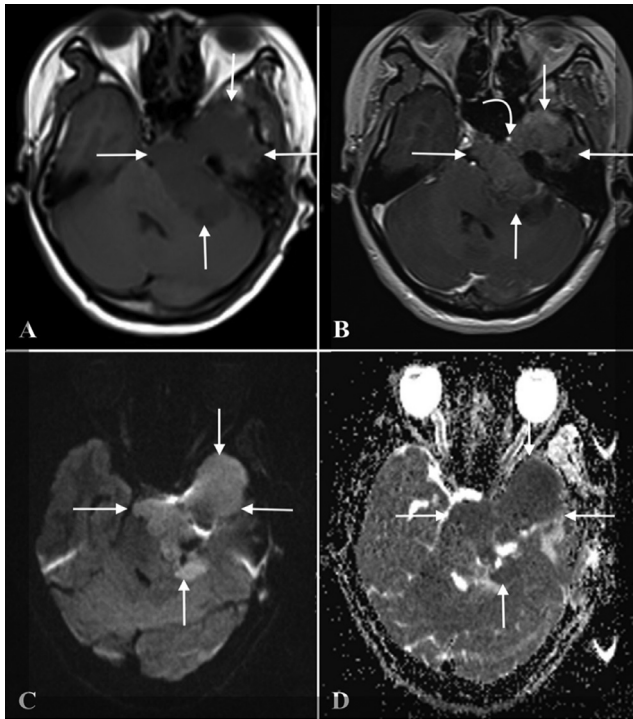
MRI brain images at 55 days postsurgery. (A) An axial precontrast T1W image showing a rapidly growing recurrent tumor in the left cerebellopontine angle (straight arrows) spreading through Meckel's cave and extending into the left middle cranial fossa, invading the cavernous sinus and surrounding the left internal carotid artery (curved arrow). The cerebellar peduncle, brainstem, and fourth ventricle were compressed and displaced to the right. (B) A postcontrast T1W image showing a contrast-enhancing lesion. The lesion with diffusion restriction appears (C) bright on DWIs and (D) dark on the ADC map.
